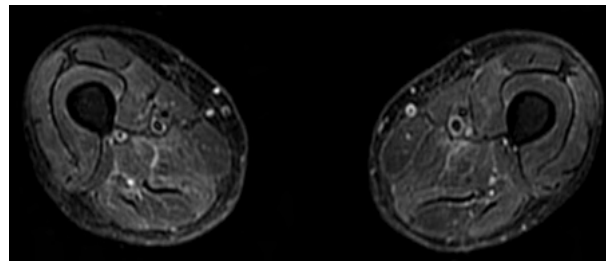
Lower limbs muscular MRI (T2 STIR). Diffuse muscular edema, predominant in posterior compartment.
